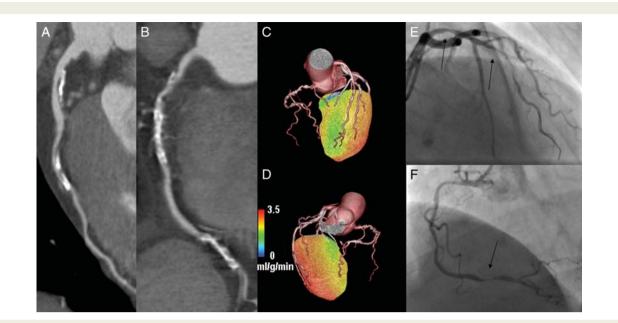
Detection of culprit lesion by hybrid positron emission tomography/computed tomography angiography imaging in a patient with two-vessel coronary artery disease. A 49-year-old man with multiple risk factors of coronary artery disease (hypercholesterolaemia, hypertension, family history, and diabetes) and atypical chest pain. Exercise test was not feasible due to severe polyneuropathy. Multiplanar reconstructions of computed tomography angiography images of the left anterior descending coronary artery (A) and the right coronary artery (B) calcified atherosclerotic plaque and luminal narrowing in the proximal and mid-left anterior descending artery as well as in the proximal and distal right coronary artery. Hybrid volume-rendered images of computed tomography angiography and myocardial perfusion during adenosine stress as assessed by ¹⁵O-labelled water positron emission tomography show area of mildly reduced (2.0–2.5 mL/g/min) perfusion as seen in green and yellow colours in the left anterior descending artery territory (C). Stress myocardial perfusion was moderately reduced (2.0 mL/g/min) as seen in green colour in the area supplied by the right coronary artery (D). Perfusion is normal (>2.5 mL/g/min) as seen in red colour in the area subtended by the left circumflex coronary artery that did not contain atherosclerosis (C and D). Consistent with the non-invasive findings, invasive coronary angiography showed significant stenosis in the distal left anterior descending artery (fractional flow reserve 0.63, *F*) that was also treated by percutaneous coronary intervention.
